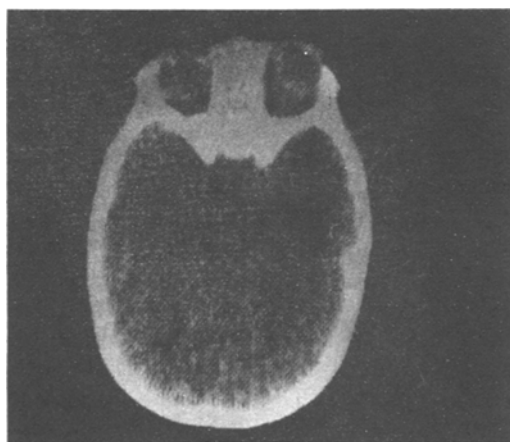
The presence of proptosis and a retrobulbar mass on the right side can be appreciated on this section of the CT scan.
